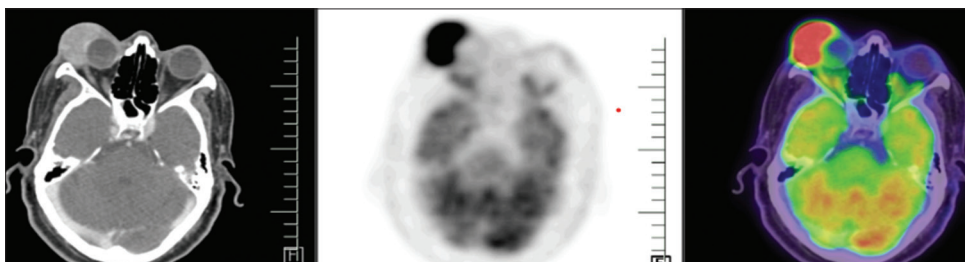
Staging positron emission tomography with computed tomography showing well-defined fluorodeoxyglucose avid enhancing 3.8 cm × 2.8cm × 3.1 cm lobulated lesion in the superior and lateral aspect of the right orbit, causing inferomedial displacement of the right globe and abutting the skin over the upper eyelid, infiltrating the lateral rectus muscle
